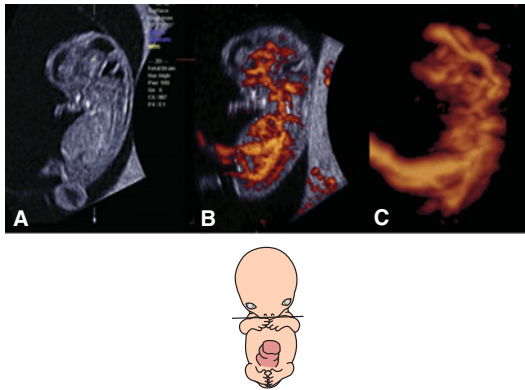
Early embryonic vascularity at 9 postmenstrual weeks. (A) Sagittal sonographic image of the fetus. (B) Three-dimensional (3D) power Doppler image of fetal vascularity with surface display mode. (C) 3D power Doppler angiographic image of the vascular system.
